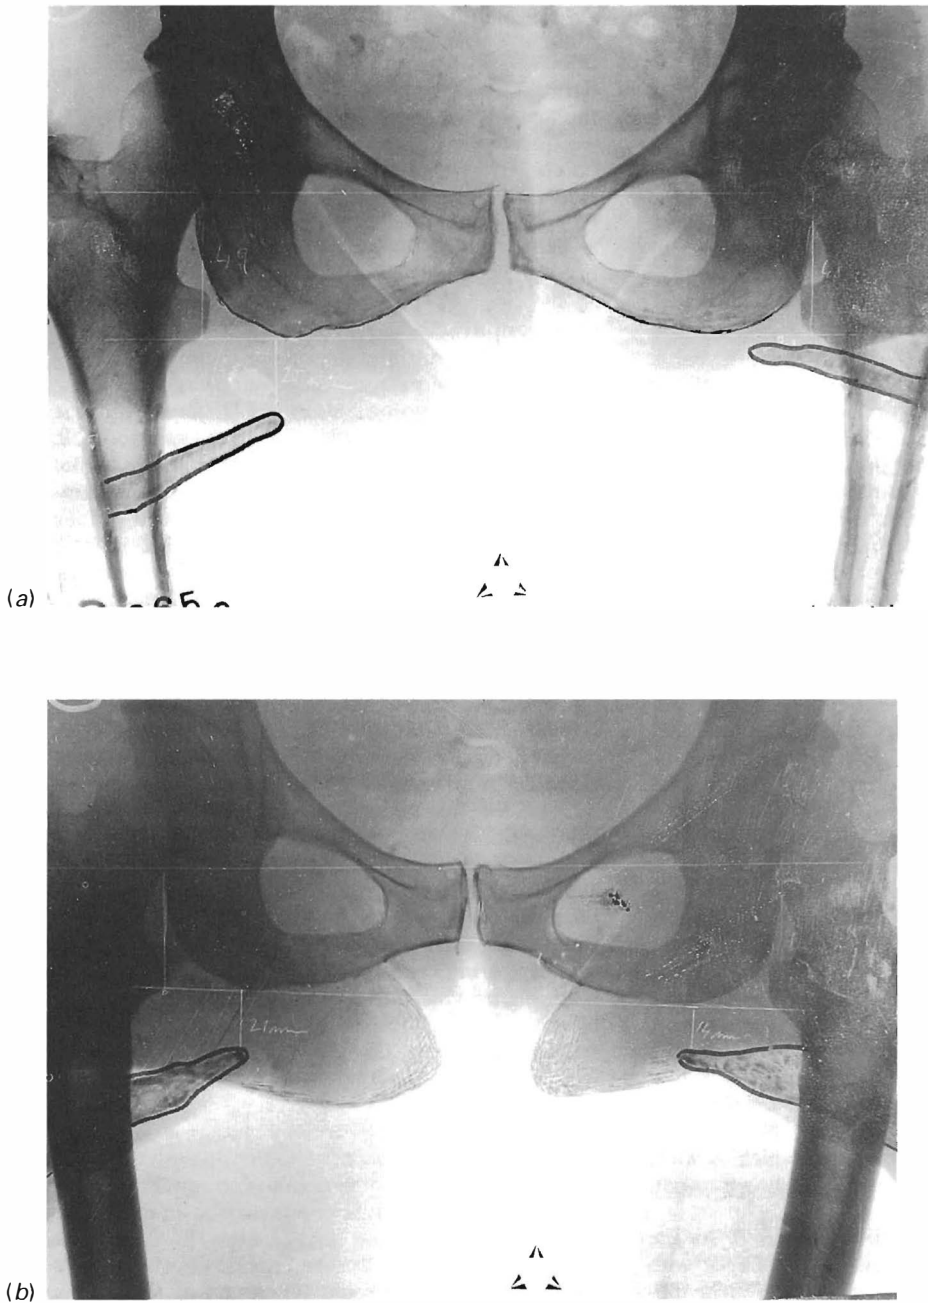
Palpatory illusion: pelvic X-ray showing symmetrical position of ischial tuberosities (a) before and (b) after treatment. What has changed is the position of the examiner's fingers
